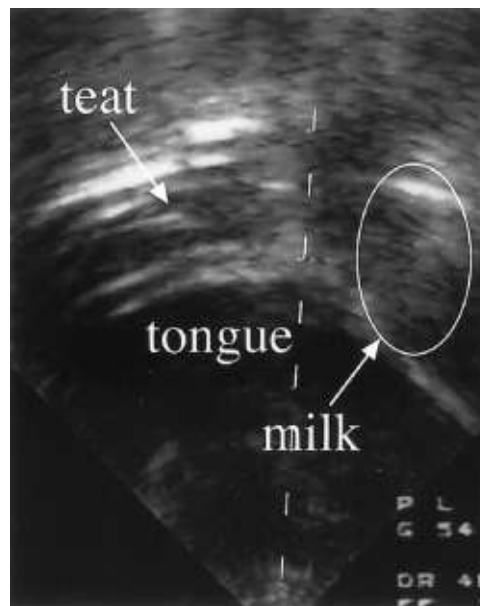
B-mode ultrasonogram of neonates with cleft palate during nutritive sucking.
